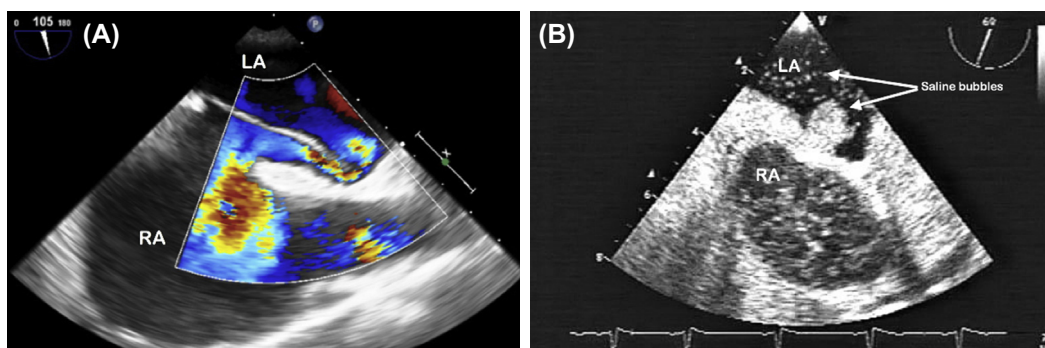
Transesophageal echocardiogram showing a PFO with resting bidirectional shunt. Color Doppler imaging confirms a left-to-right shunt (A) and bubble study confirms right-to-left shunting (B). *LA*, left atrium; *RA*, right atrium.
